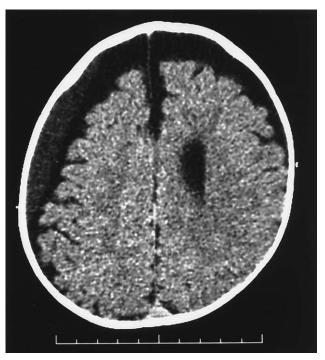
Unenhanced head CT shows benign enlargement of the subarachnoid spaces, with right frontoparietal subdural hematoma. There is flattening of the left parieto-occipital region.
